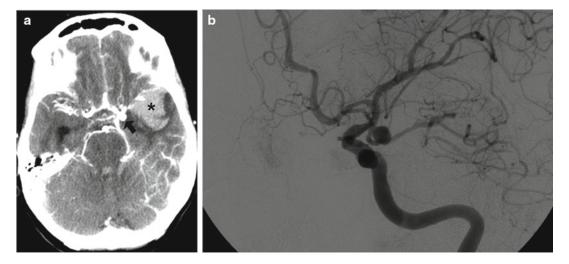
(a) CT angiogram demonstrating a left temporal intraparenchymal hemorrhage (*asterisk*) and a 5×7 -mm left posterior communicating artery aneurysm.
